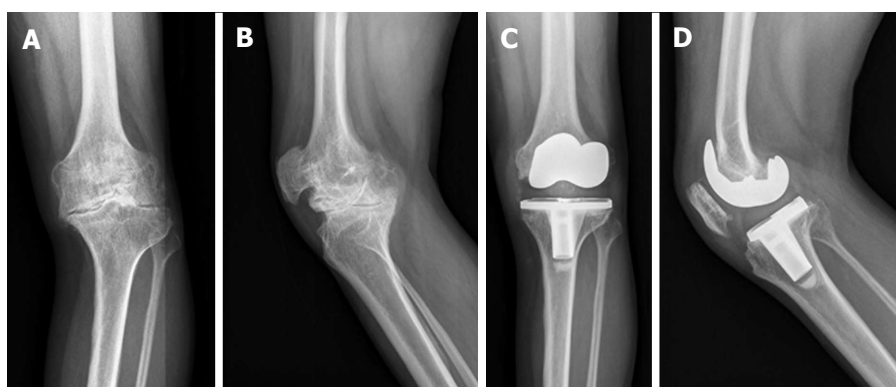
Severe painful hemophilic arthropathy of the left knee in a 41-year-old male. A cemented total knee arthroplasty (NexGen, Zimmer, United States) was performed with a satisfactory result: A: Anteroposterior preoperative radiograph; B: Lateral preoperative view; C: Anteroposterior radiograph 5 years later; D: Lateral view at 5 years. The quality of life of this patient improved significantly.
